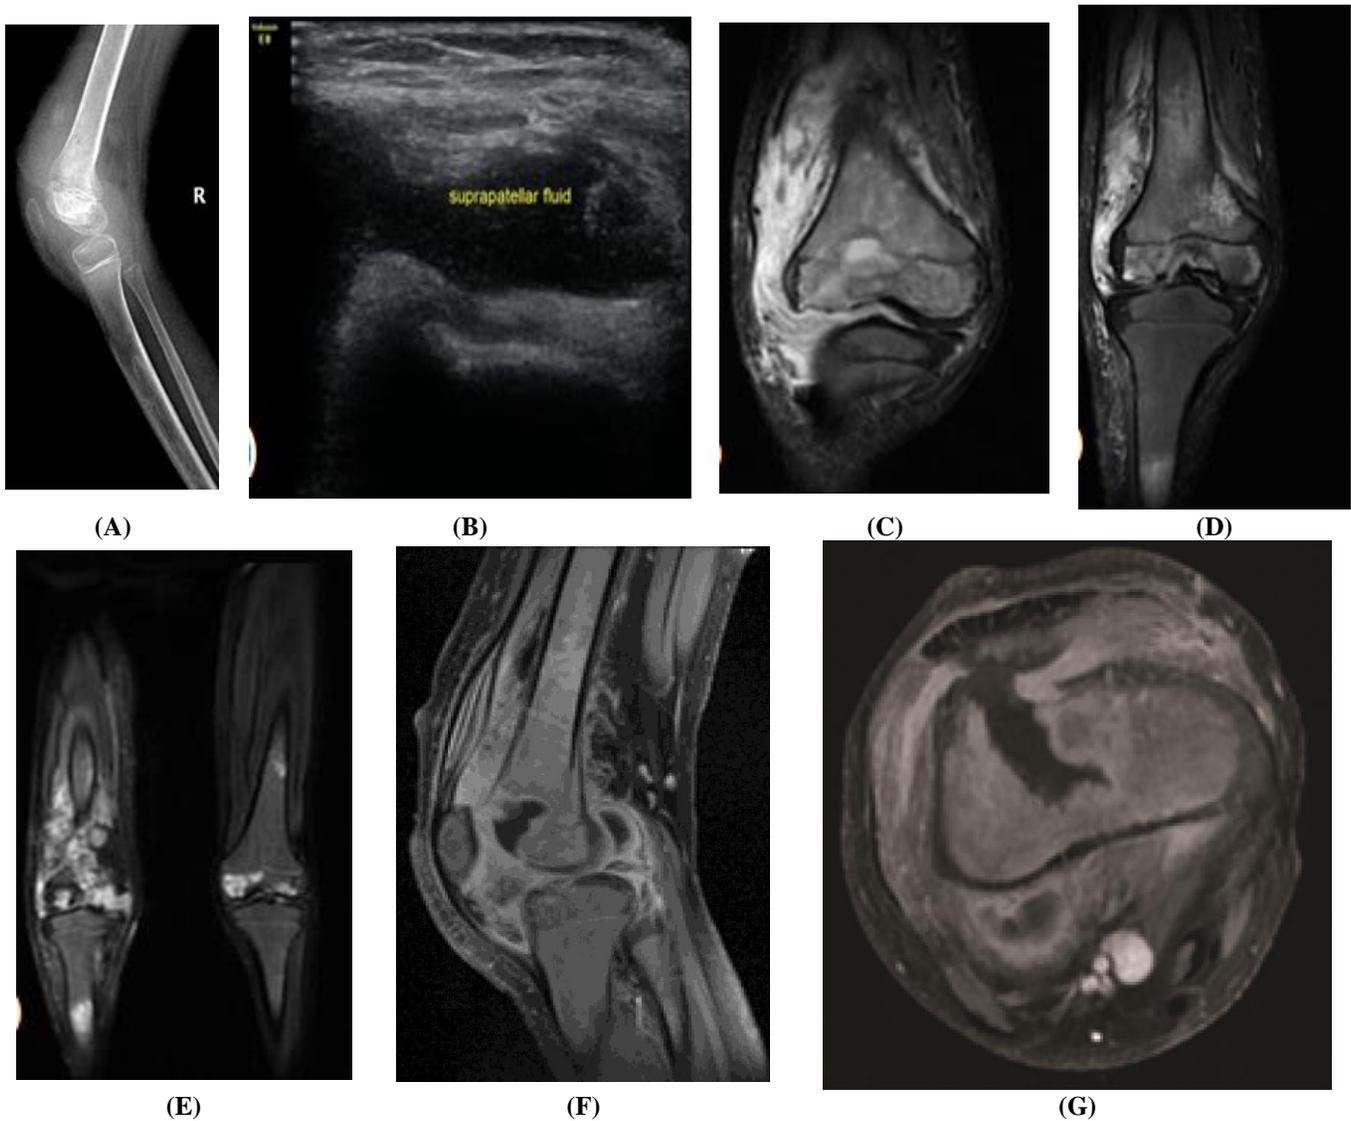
6 years old girl with history of Sickle cell disease complain of right knee pain low grade fever by blood culture show increased inflammatory markers. (A) Radiography of right knee joint lateral view shows a small lytic lesion at the medial aspect of lateral femoral metaphysis near the growth plate with serpinginous area of calcification as well as joint soft tissue swelling. (B) High resolution US axial view shows suprapatellar turbid effusion. (C,D&E) MRI coronal STIR of right femur (F&G) Sagittal and axial right femur T1 fat suppression post IV contrast show focal area of bone marrow low signal intensity lesion affecting the distal femoral metaphysis, and extending through the growth plate to the distal femoral epiphysis and reaching the knee joint space through fistulous tract formation associated with cortical defect. There is extensive intra and extra articular soft tissue edema involving the lower third of the thigh muscles.
